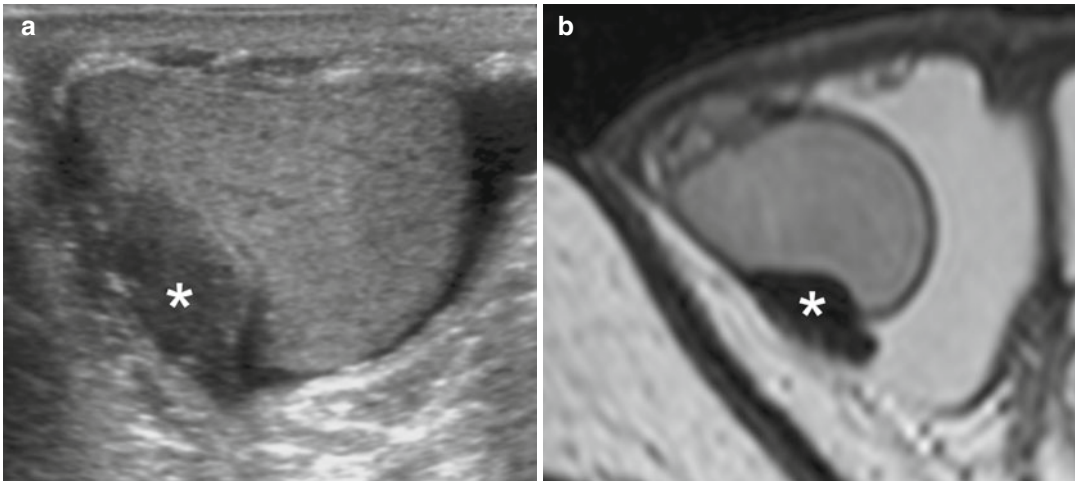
Fibrous extratesticular pseudotumor. (a) Ultrasonography shows a hypoechoic lesion (*asterisk*) causing compression of the testicular parenchyma arising from the tunica
